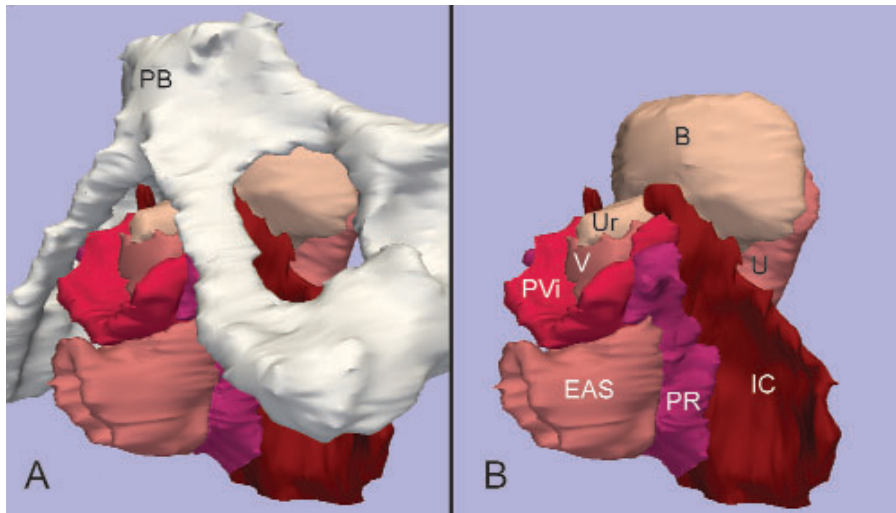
Three-dimensional model of levator ani subdivisions including the pubic bone and pelvic viscera. This model was created by using the magnetic resonance images shown in Figures 2, 3, and 4. The pubovaginal, puboperineal, and puboanal muscles are all combined into a single structure, the pubovisceral muscle. Inferior, left 3-quarter view. B. The same model without the pubic bone. PB, pubic bone; V, vagina; U, uterus; Ur, urethra; B, bladder; IC, iliococcygeus muscle; PR, puborectal muscle; PVi, pubovisceral muscle; EAS, external anal sphincter [36].
